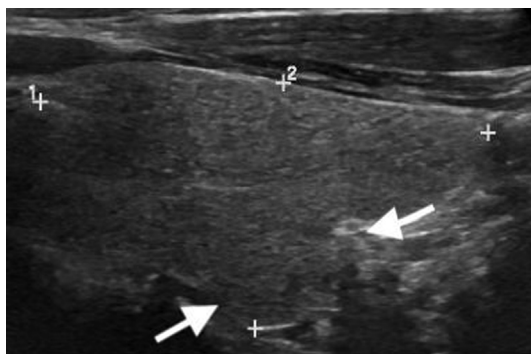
(A) Sagittal grayscale ultrasound image of the thyroid (*calipers*) with bulging of the anterior portion (*arrows*), which suggests an enlarged gland. (B) Transverse grayscale ultrasound image of an enlarged left lobe of the thyroid (*calipers*) extending over the carotid artery (C).
